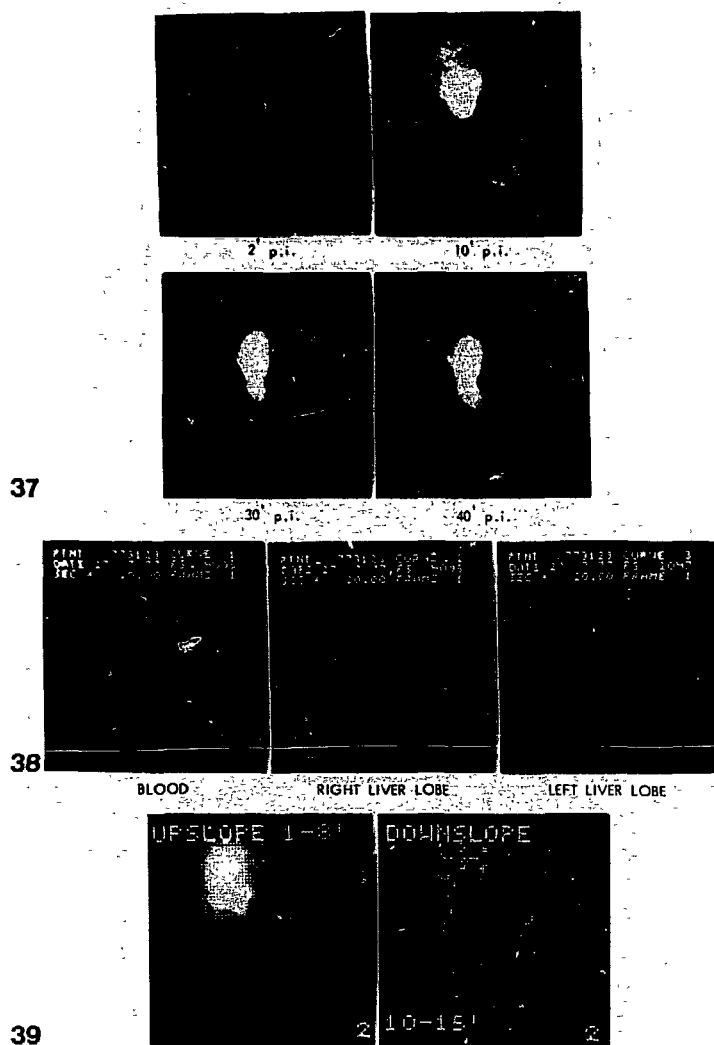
37-39 Cholescintigraphy in a patient with probably acute viral hepatitis.
